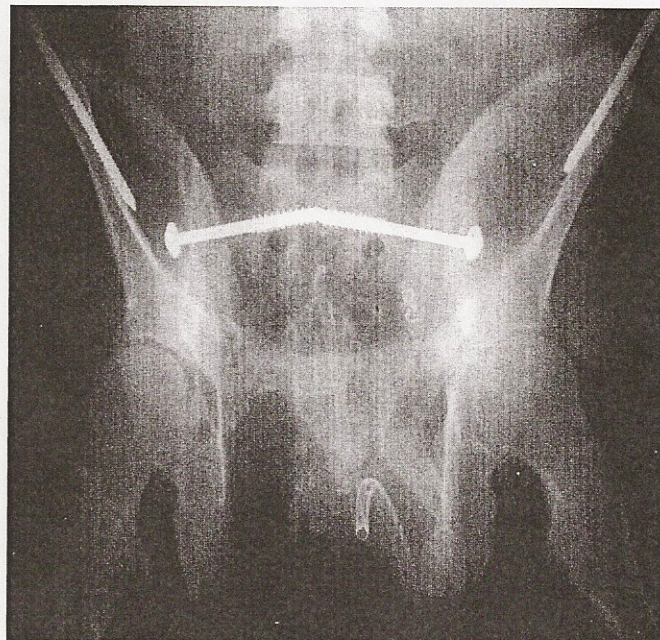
Anteroposterior radiograph with a simple two-pin anterior frame applied (with the sheet secured). The sheet was then removed, and bilateral percutaneous sacroiliac screws were inserted.
